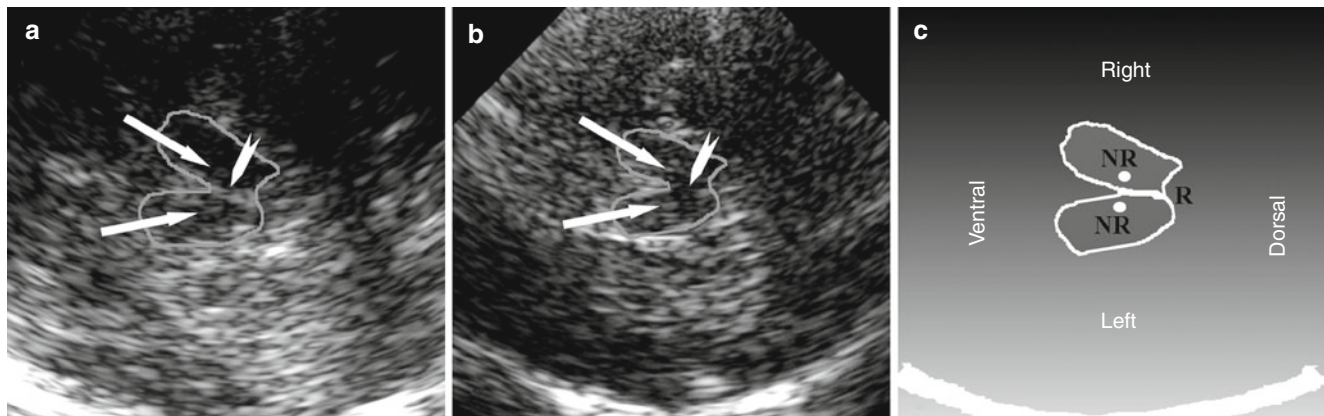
Brainstem raphe in an axial sonogram of the midbrain. (a) Abnormal finding: despite good visualization of the nucleus ruber bilaterally (arrows), the brainstem raphe (arrowhead) is not represented; a significantly reduced echogenicity is noted. (b) Unremarkable finding:
